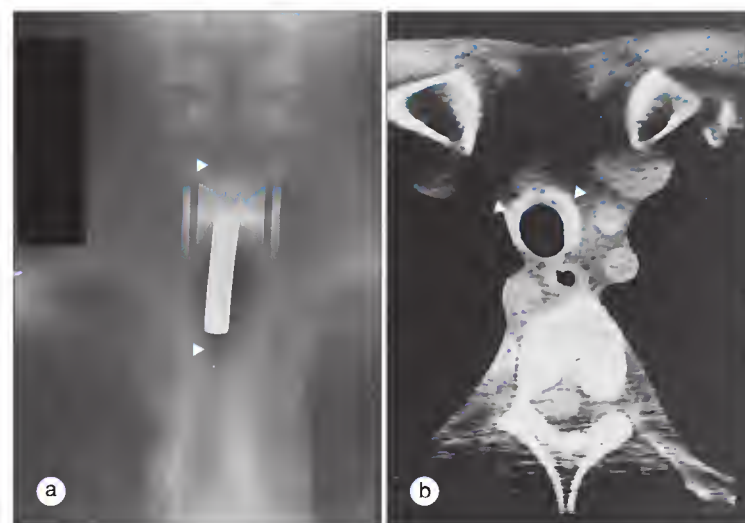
Localized tracheobronchial obstruction due to relapsing polychondritis. (a) The radiograph shows both narrowing in the larynx above the tracheostomy tube and tracheal stenosis below (arrowheads). (b) Computed tomographic scan of the trachea shows the thickening of the tracheal wall due to inflammatory changes (arrowheads). Note how the posterior, noncartilaginous portion of the trachea is spared.
